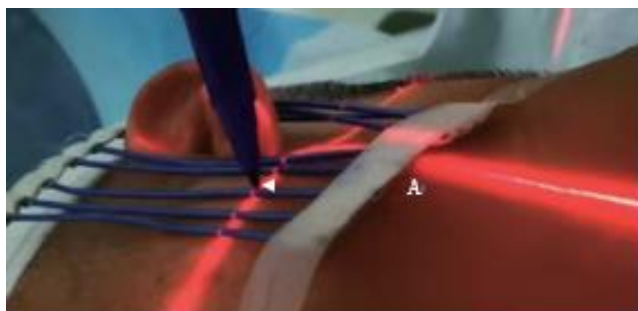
Find the puncture plane and mark the puncture point with the CT positioning red line.
